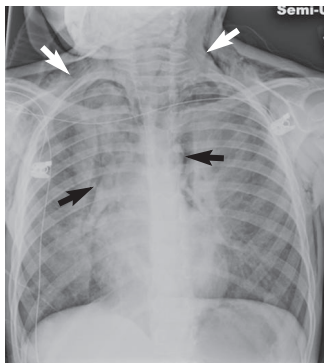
Chest radiograph of an 8-year-old asthmatic taken during an acute exacerbation. There is extensive mediastinal air evident around his heart and tracking upward into his neck and supraclavicular soft tissues (arrows).
